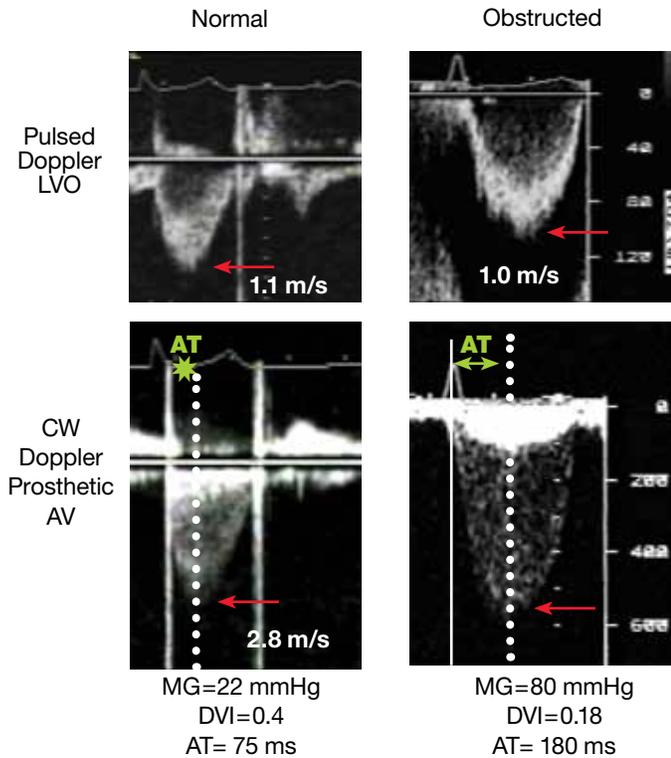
Doppler recordings of a normal and obstructed prosthetic valve in the aortic position. With obstruction, the jet velocity increases and undergoes changes in the contour. AT = acceleration time; MG = mean gradient; DVI = Doppler velocity index, ratio of velocity in the LV outflow to velocity through the prosthesis. Reproduced from Zoghbi et al.¹
